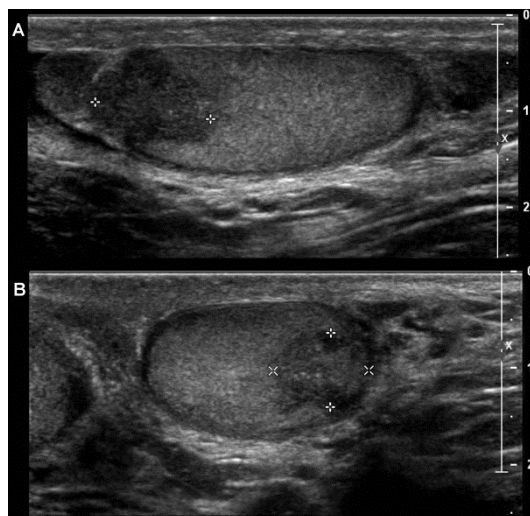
Testicular ultrasound images. (A) sagittal and (B) coronal sections show an injury (indicated with white crosses) of 7 mm × 10 mm × 12 mm, which is hypoechoic, heterogeneous, and vascularized, with calcifications.
